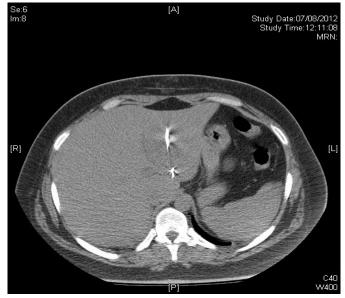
Drainage under CT control
